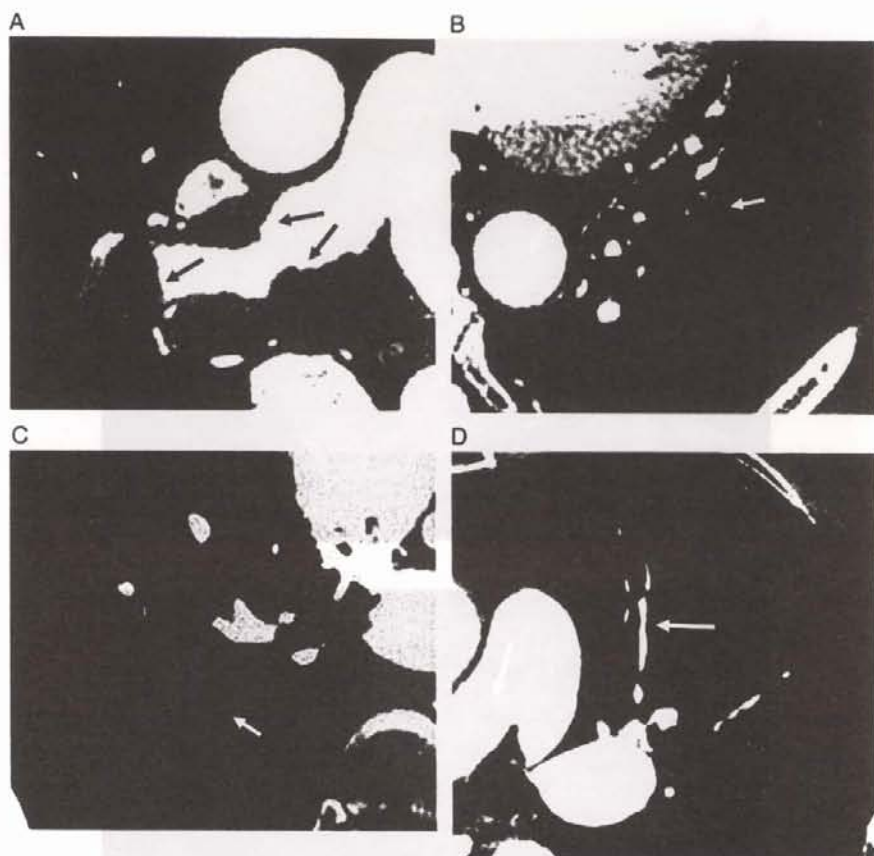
Actual measurement of CT vascular obstruction index (VOI) for pulmonary arterial (PA) thromboembolism using axial source images of enhanced multislice CT. A: There are thrombi (arrows) which partially block the right main PA. We counted the thrombi distally from the segmental arteries. In this case the obstruction score was 20 points. B: There is a thrombus (arrow) which totally blocks the A8 and A9 segments of the left PA; the score of the thrombus was calculated as $2 + 2 = 4$ points. C: There is a thrombus (arrow) partially blocking the A10 segment of right PA; the score of the thrombus was 1 point. D: There were intimal irregularities (arrow) in the PA and the findings were diagnosed as the presence of a partial obstructions; the score of each thrombus was calculated as 1 point.
